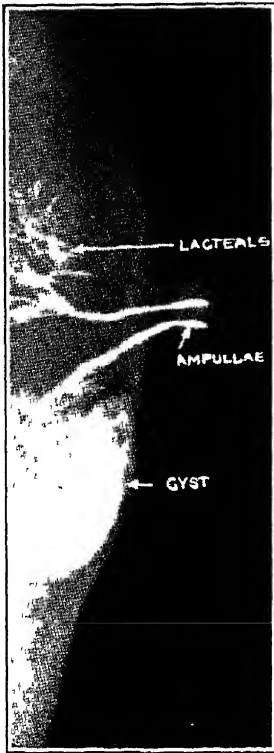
A collapsed cyst became visible and palpable by introducing thorotrast into some of the discharging ducts. The upper segment is that of an involuted breast (Am J Roentgenol, March, 1938)
